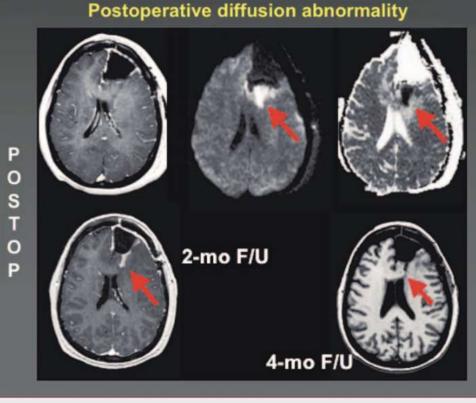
DWI obtained 2 and 4 months postoperatively to identify areas of ischemia (bright signal DWI, dark signal void apparent diffusion coefficient) that enhances briefly postoperatively.
